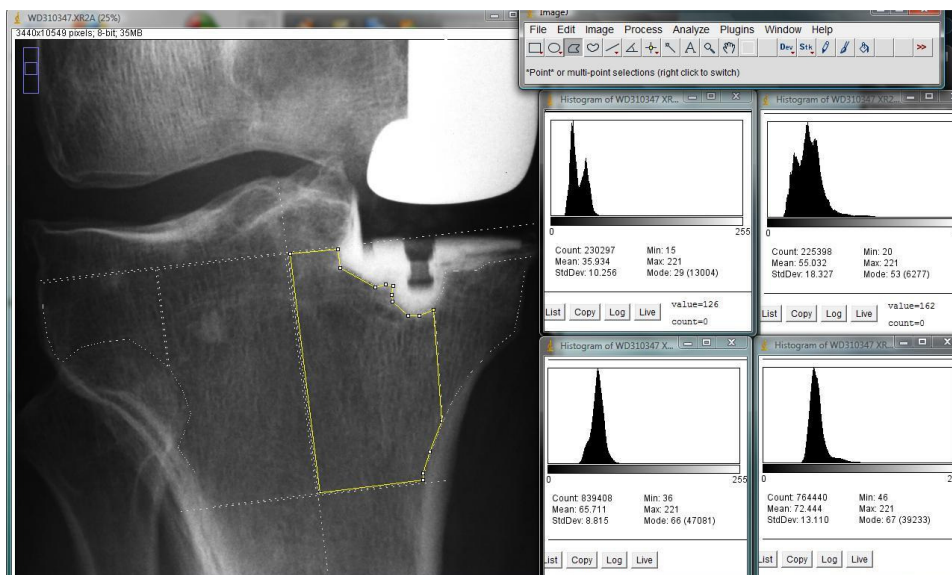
Postoperative radiograph analysis. The 4 ROIs have been delineated with exclusion of the fibular head, cortical condensations and cement. This is the same patient as figure 2.8.
